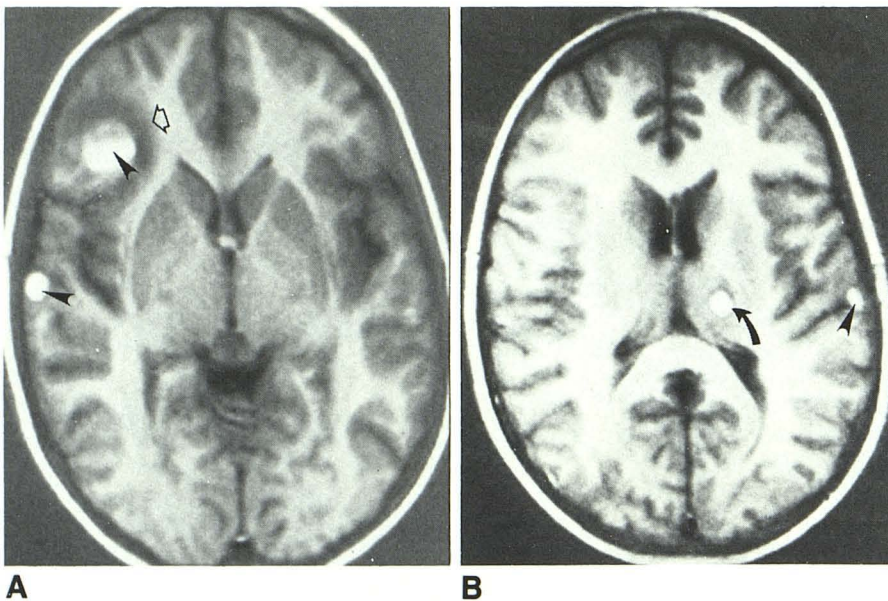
15-year-old girl. Axial T1-weighted inversion-recovery (TR = 2100 msec, TI = 600 msec) MR images 6 days after trauma show multiple hemorrhagic cortical contusions along inferolateral aspects of frontal and temporal lobes (arrowheads). Hemorrhagic nature of contusions is evident by short T1 of methemoglobin within hematomas. Peripheral nonhemorrhagic zone of injury and edema (open arrow) is hypointense because of its long T1. Note hemorrhagic subcortical gray-matter lesion in thalamus (curved arrow). This type of lesion may result from shear-strain disruption of perforating blood vessels.
